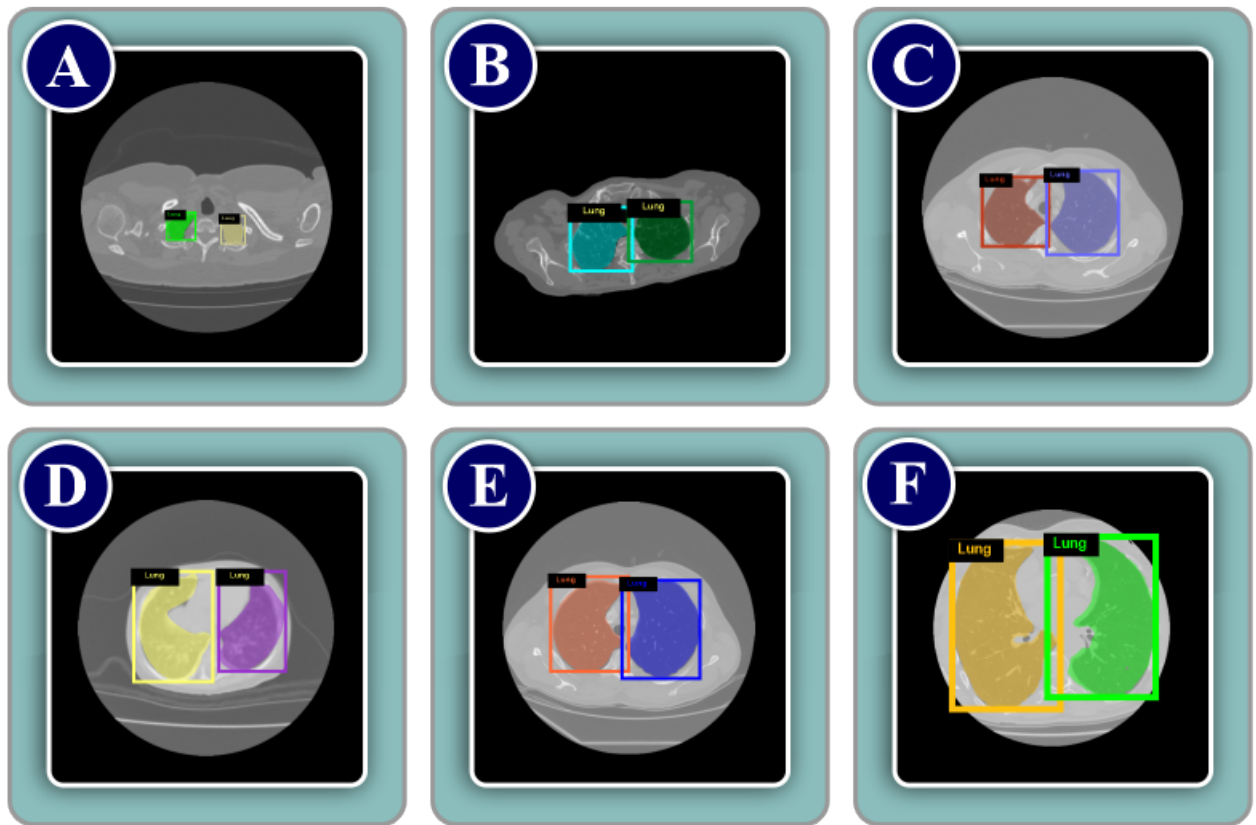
Results of segmentation of the proposed method for different chest CT slices
